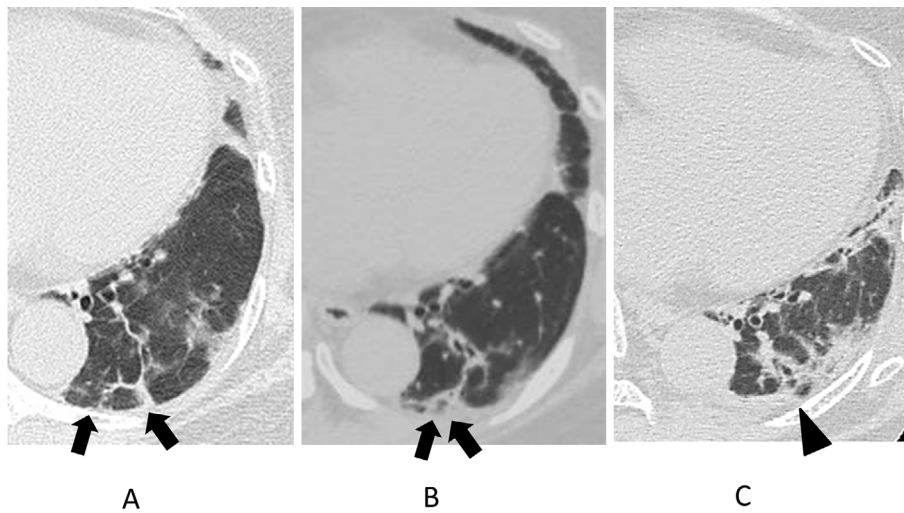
Follow-up CT findings in Case 3. (A) Perilobular opacity (arrows) was observed in the left lower lobe on admission. (B) Follow-up CT showed the thickening of perilobular opacity (arrows) three days after admission. (C) The perilobular opacity progressed to consolidation with the loss of lung volume (arrowhead) about two weeks after admission.
